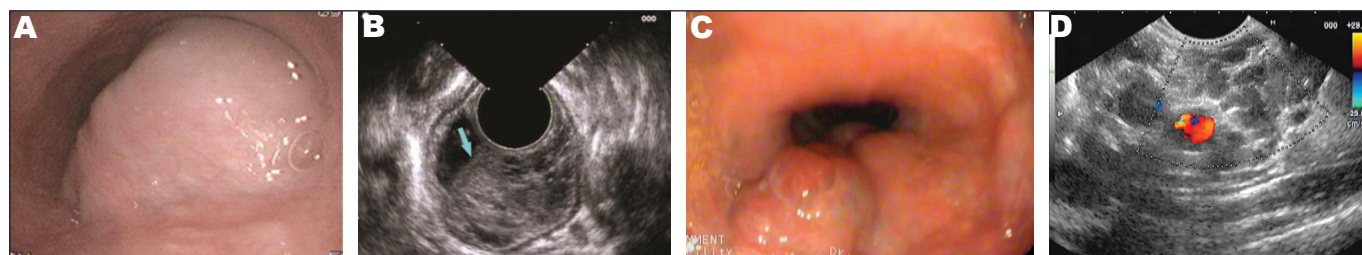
A: Endoscopic view showing a solitary lesion in the esophagus; B: Endoscopic ultrasound (EUS) showing a multiple cystic mass arising within the submucosa; C: Endoscopic view showing a cluster in the esophagus; D: EUS showing diffuse cavernous hemangioma extending into adjacent structures by infiltrating the submucosa and beyond.
